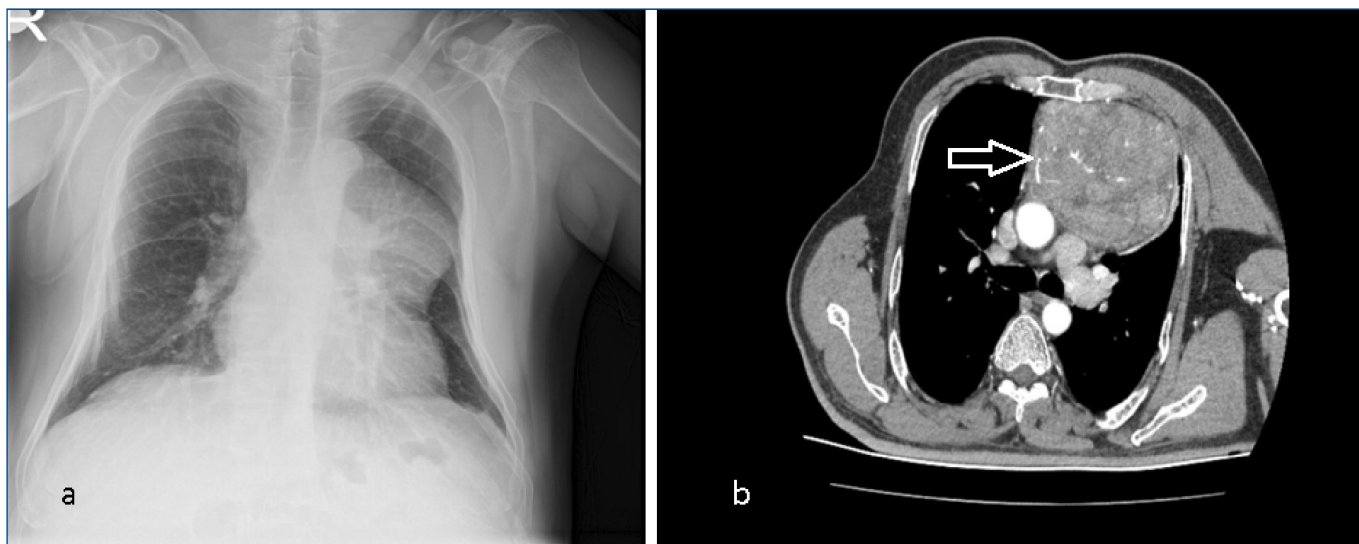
a. Postero-anterior chest radiograph, b. Mass lesion in the anterior mediastinum on computed thoracic tomography
